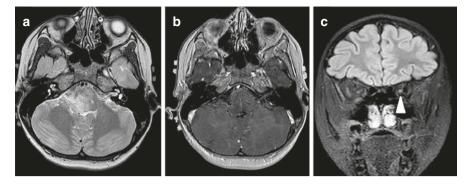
Brainstem involvement in aquaporin 4-positive neuromyelitis optica. (a) Signal abnormality within the pons on axial FLAIR images. (b) Absence of enhancement on axial post-contrast T1-weighted images. (c) Left-sided optic neuritis on coronal T2-weighted images
